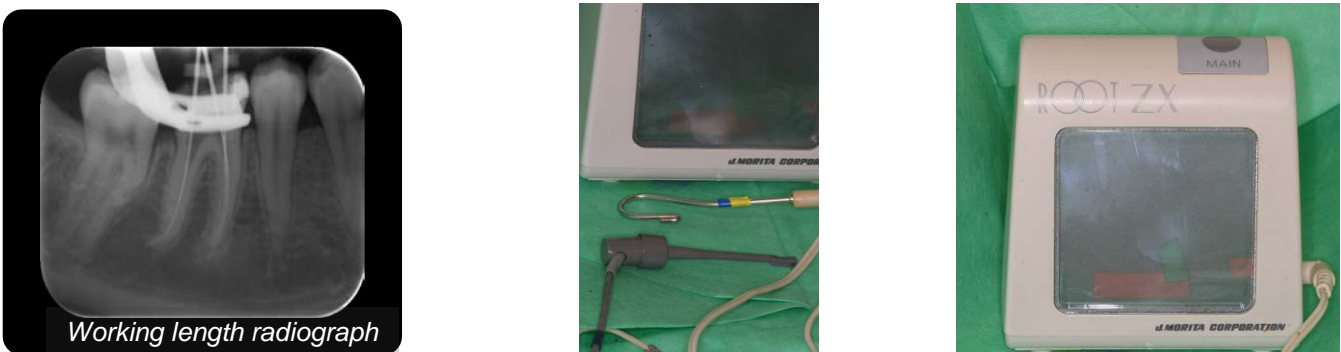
WL X-ray (left). Apex locator used, the ROOT ZX®
